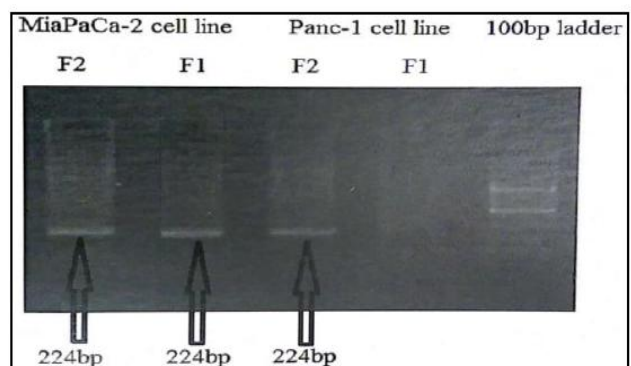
Agarose Gel Electrophoresis. Representative result showing polymorphism status of CHD-5 gene at 4615 in MIA PaCa-2 cell line showing genotype CT
